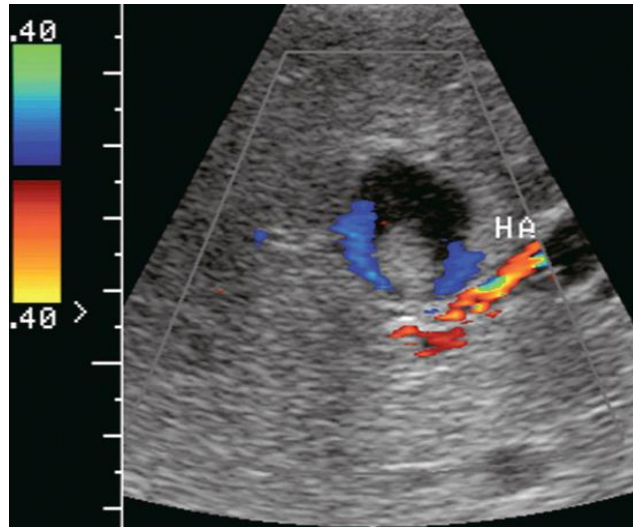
Transverse colour Doppler image of the mid-liver. A rounded lesion is present with some internal debris. Flow is perceived around this debris. A turbulent arterial spectral Doppler waveform was identified at the neck. Angiography confirmed that this was a partially thrombosed intrahepatic hepatic artery aneurysm. (Myron A. Pozniak et al, 2014)
